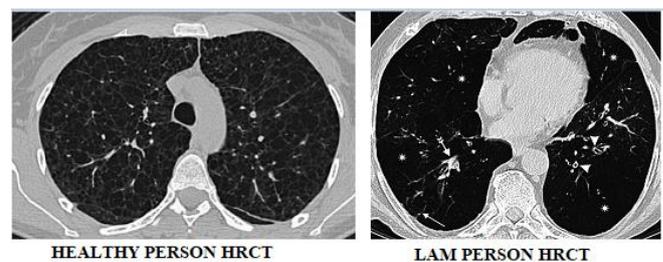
Dataset of Healthy and Lam affected Lung HRCT
